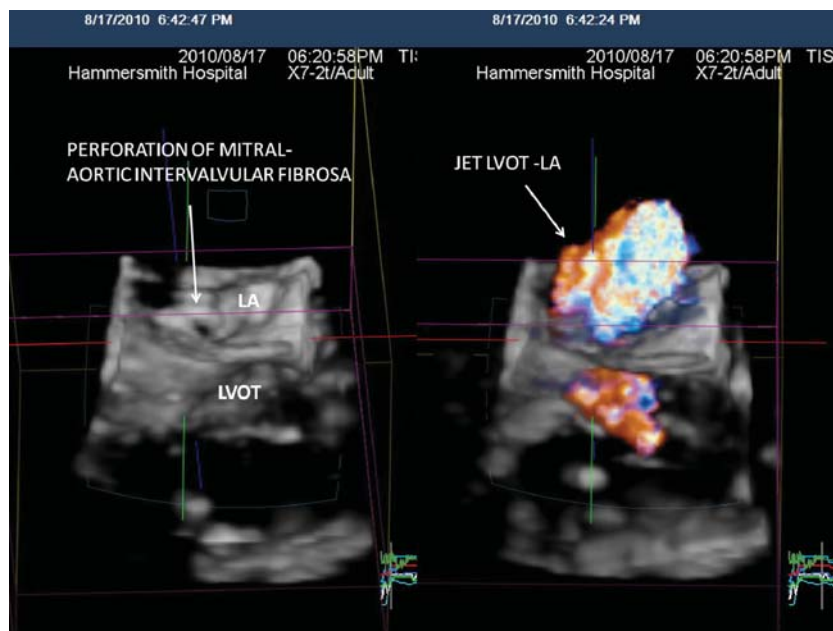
Trans-oesophageal echocardiogram: four-chamber view in which a jet originating in the left ventricular outflow tract causes severe regurgitation in the left atrium. LA, left atrium; Ao, aorta; LV, left ventricle.
